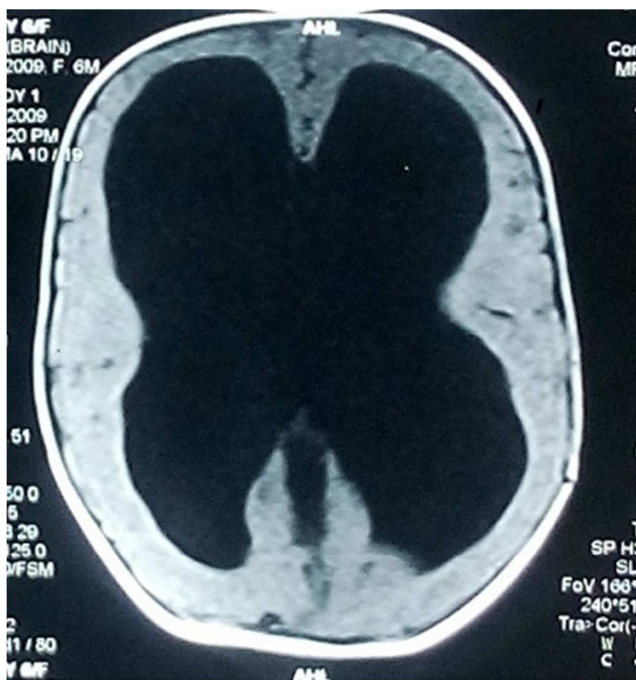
MRI brain T2WI showing gross hydrocephalus with dilatation of lateral ventricle and third ventricle with prominent temporal horn.
